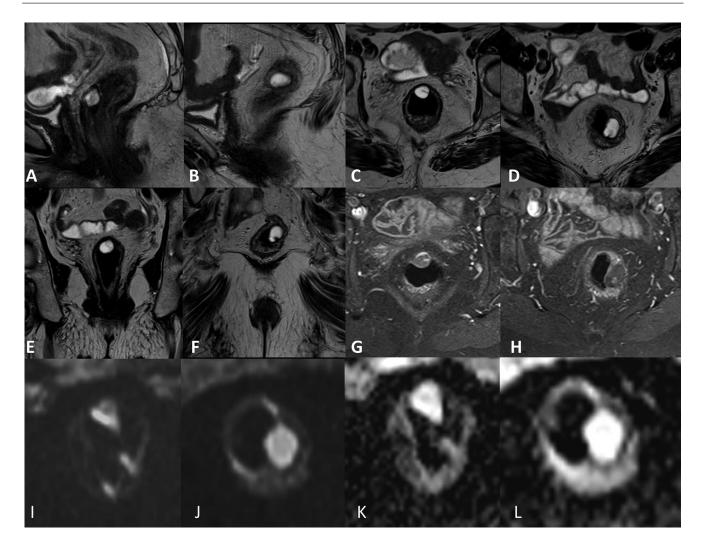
(A-F): T2-weighted MRI showing the presence of 2 cystic lesions of the rectal wall with an epicenter in the submucosa (A and B: sagittal plane; C and D: axial plane; E and F: coronal plane). (G and H): T1-weighted fat suppressed MRI in axial plane obtained after administration of contrast medium showing only peripheral enhancement of rectal cysts. (I and J): Diffusion-weighted imaging (DWI) MRI and (K and L): Apparent diffusion coefficient (ADC) in axial plane do not reveal diffusion restriction.
